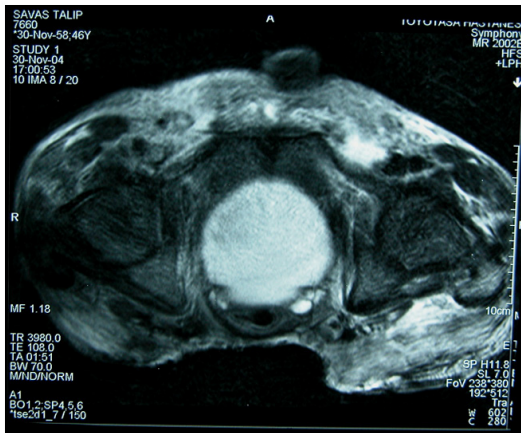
Pelvic axial fat-suppressed T2-weighted MRI: Subcutaneous tissue, presacral fascia, muscles and coccyx are resected (Bold white arrows) and bilateral inguinal lymphadenopathy (thin white arrows).
